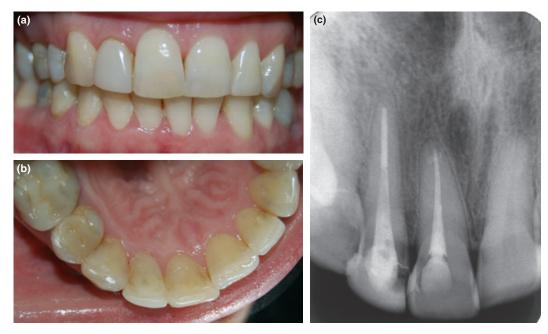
(a) Frontal intra-oral view of reattached tooth 11 months after the reattachment. Note the excellent adaptation between the crown fragment and involved tooth at the cervical aspect. (b) Palatal view of restoration. (c) Periapical radiograph showing no pathological alteration in the periapical region.
